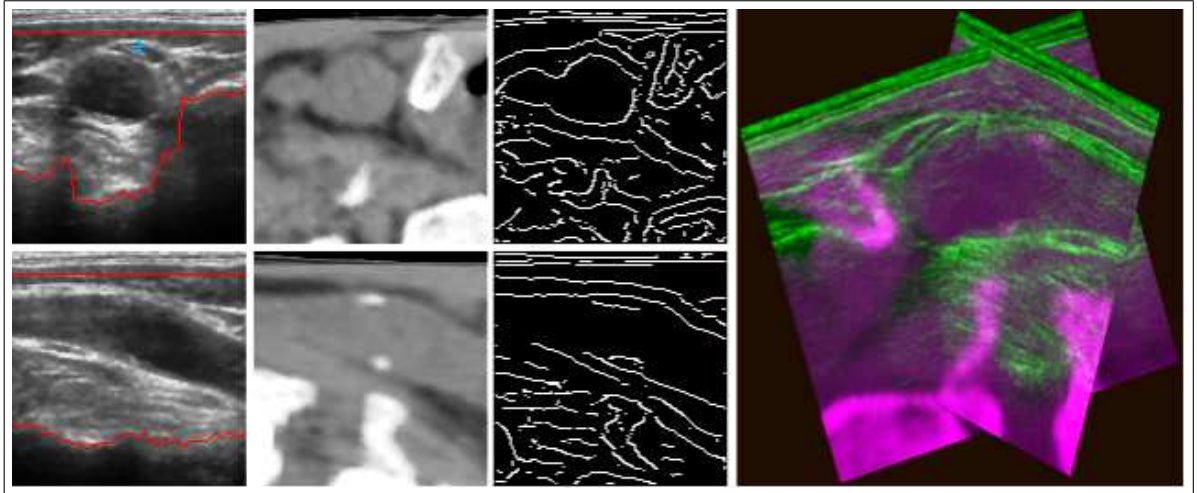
Two ultrasound images with ROI (red lines) and target, corresponding CT slices, edges from CT, and overlay in 3D. The physical image size is 4 by 4cm [46].
